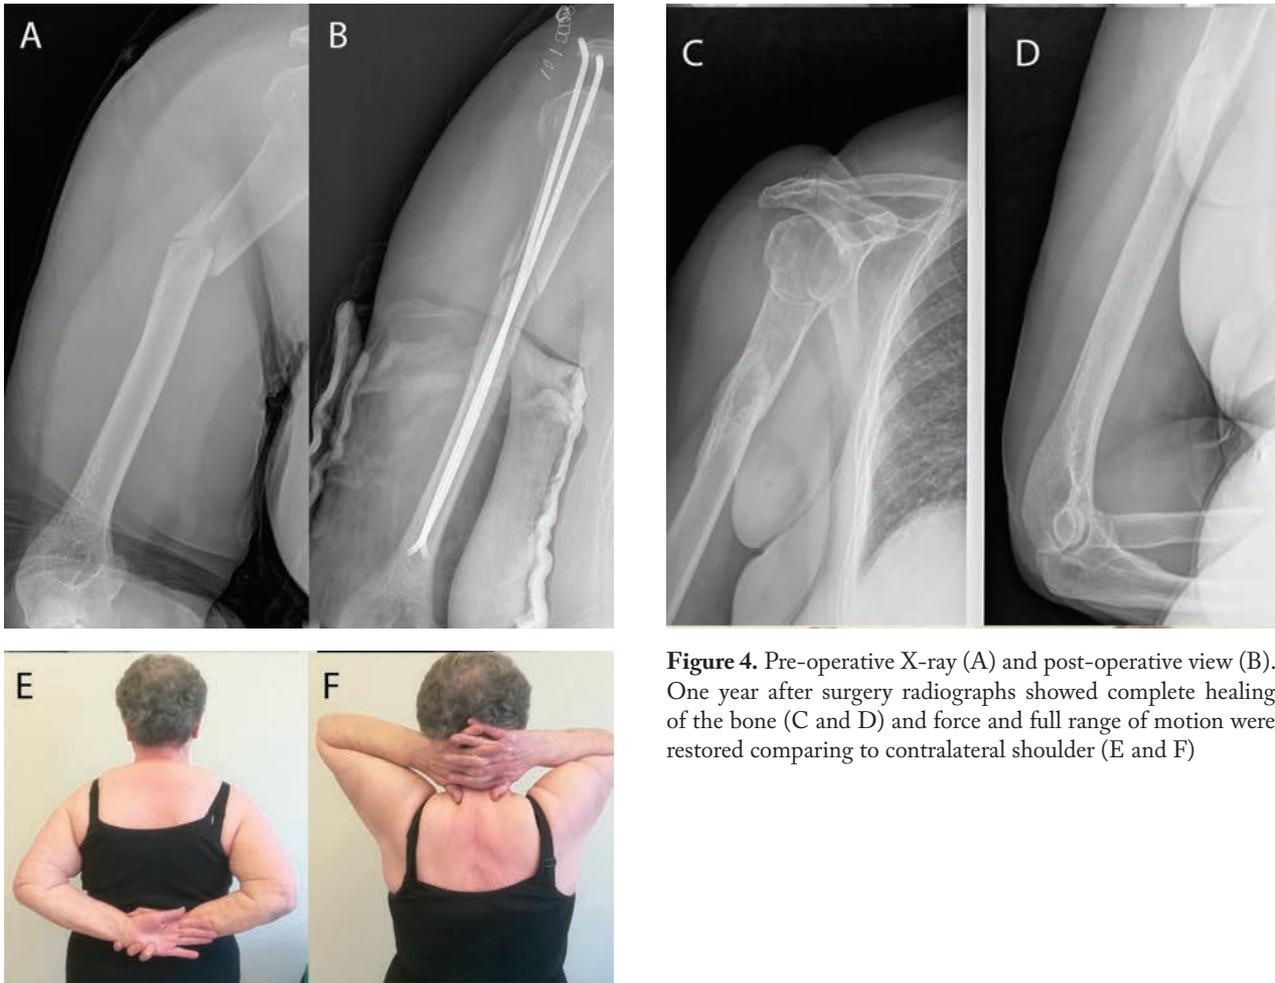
Pre-operative X-ray (A) and post-operative view (B). One year after surgery radiographs showed complete healing of the bone (C and D) and force and full range of motion were restored comparing to contralateral shoulder (E and F)
